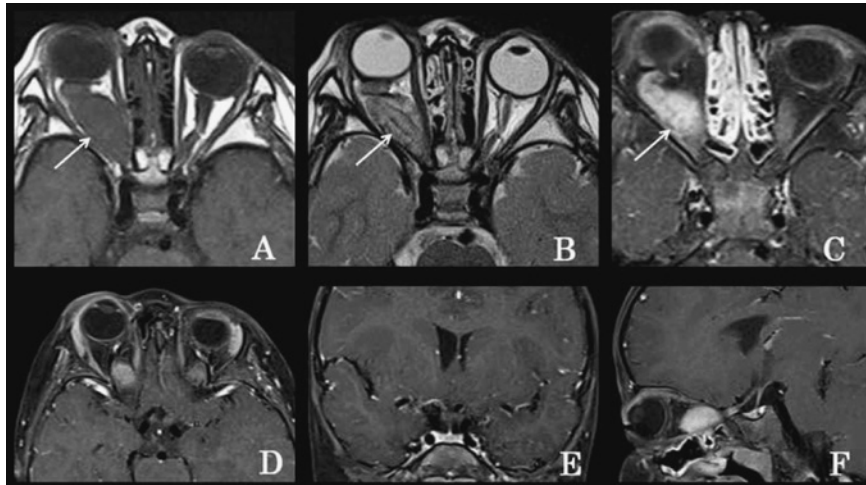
Preoperative MRI scans
